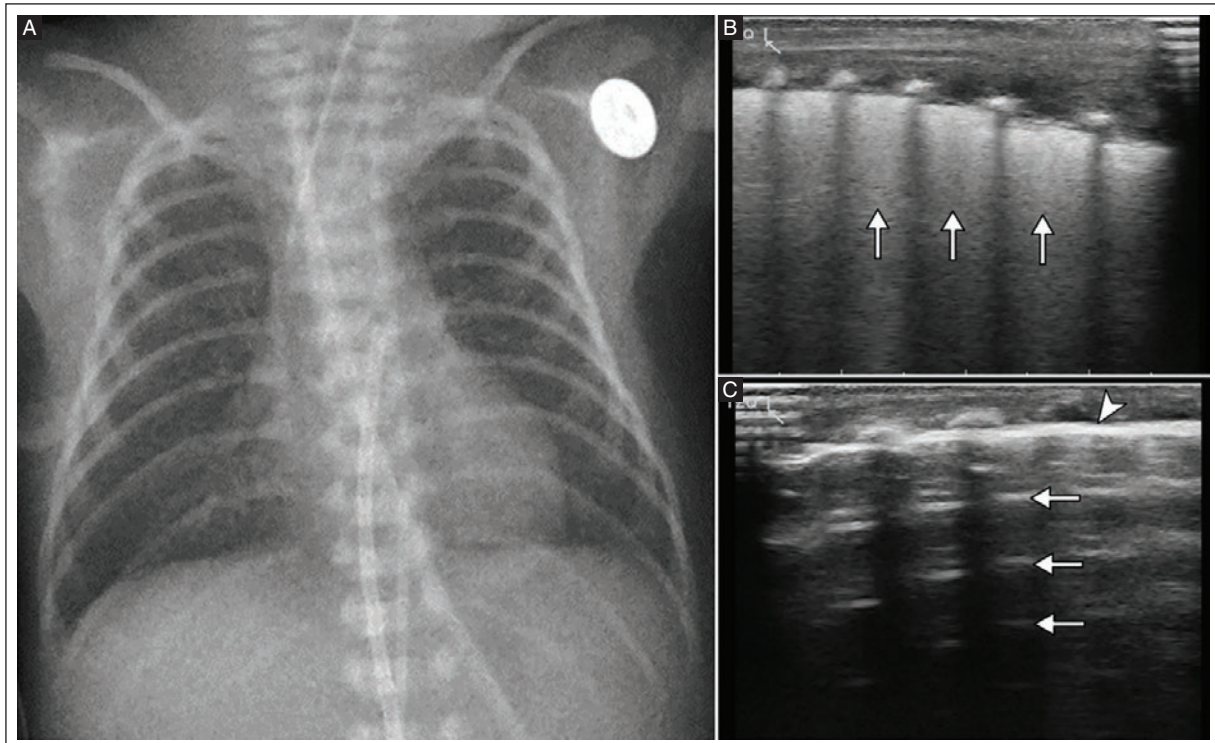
Full-term male neonate born by cesarean section at 38 weeks gestation with 24 hours of extrauterine life with an NRD and clinical suspicion of TTN. A: AP chest X-ray showing adequately expanded lung fields with no pathologic abnormalities. An endotracheal tube, an umbilical catheter and a gastric tube are visible. B: lung POCUS of the left posterior-inferior quadrant shows an increased number of B-lines resulting in a "white lung" appearance (wet lung pattern) (white arrows), along with obliteration of the A-lines, a finding consistent with interstitial fluid overload. C: lung POCUS of the left anterior-inferior quadrant with preserved A-lines (white arrows) and normal appearance of the pleural line (white arrowhead), consistent with a normal ultrasound pattern. The chest X-ray was normal. Shortened lung POCUS diagnosis was interstitial fluid overload.
